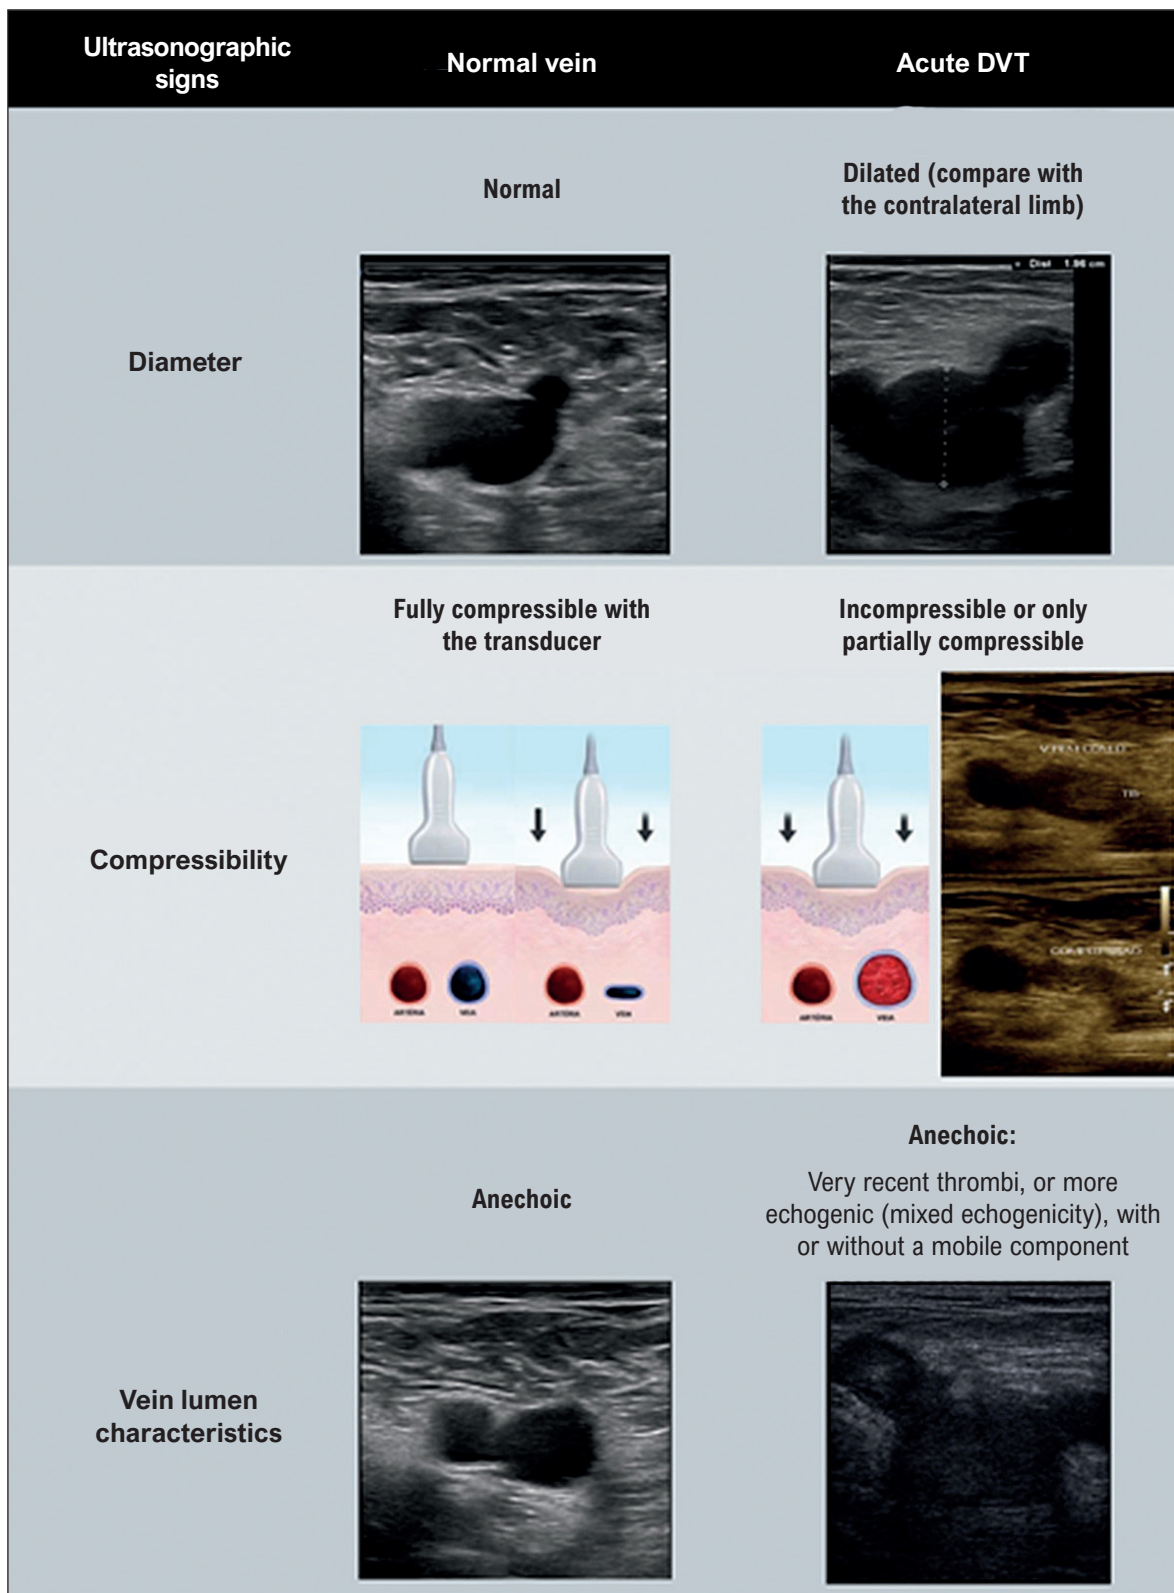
Ultrasound findings in normal veins and veins with signs of acute.
